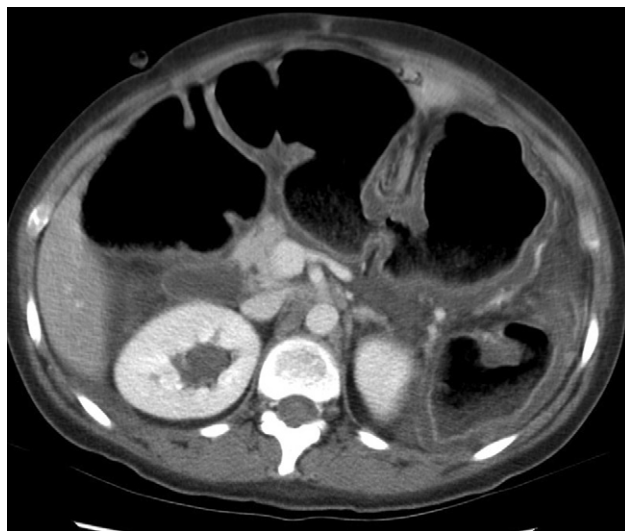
Toxic megacolon demonstrated on CT. The transverse and descending colon are thick-walled and inflamed with enhancement of the mucosa and marked dilatation of the lumen.
